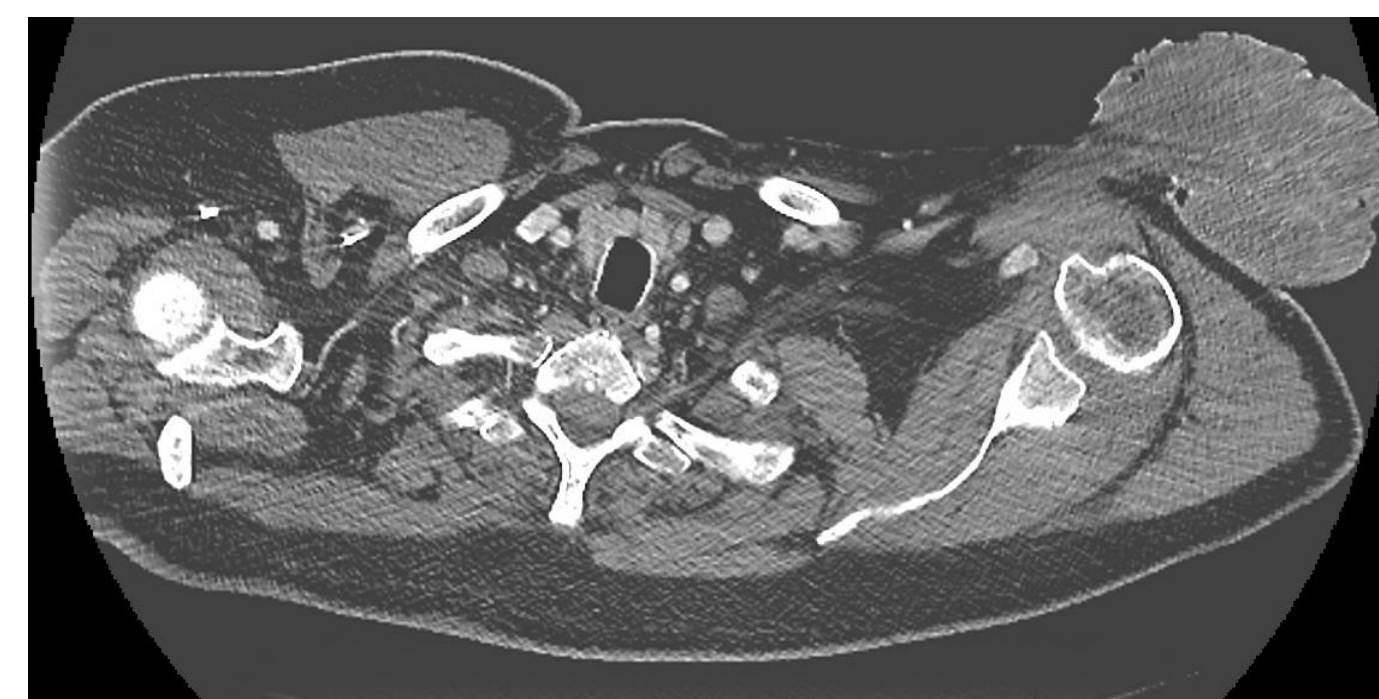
(Top Left): [CT of the chest with intravenous contrast (axial) demonstrating vascular exophytic mass which penetrates the upper left chest wall at the level of the humeral head and appeared to originate from the anterior border of the deltoid muscle.]
